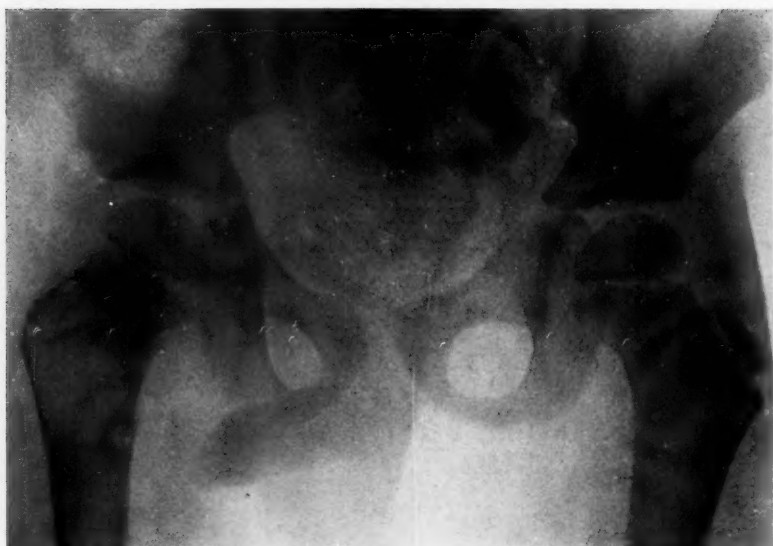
Case XII. X-ray taken five weeks later (same patient), showing fracture of the femur at upper end of the lesion; practically no deformity present, probably due to the fact that at the time of accident patient was wearing a spica plaster-of-Paris dressing.
